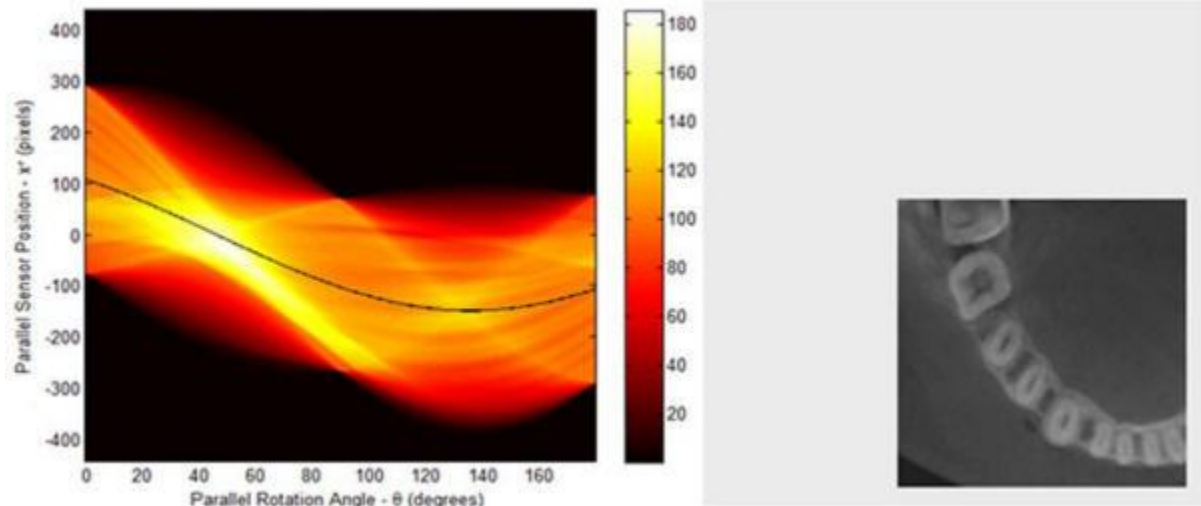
Raw data from a CT scan are processed by computer to make a meaningful image (Image by Kyungtaek Jun & Seokhwan Yoon, Wikimedia Commons)
